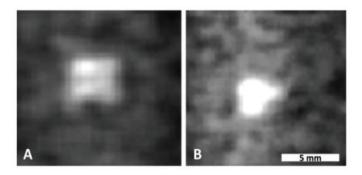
MRI of novel contrast agent. MRI results with no voltage applied (A) and with voltage applied (B). A 5% change in MRI signal is observed with electric fields of 20 V/m (comparable to the field within 10 µm of neurons).
